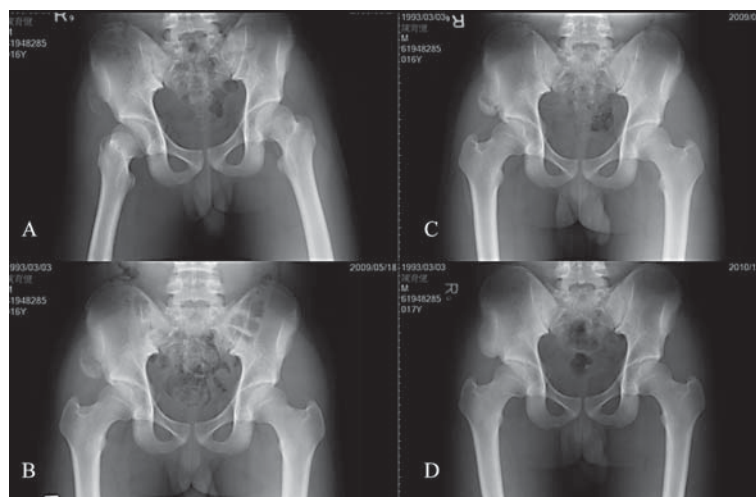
A series of radiographs of the young athlete with avulsion fracture of the anterior superior iliac spine (ASIS) show the healing process. A. Initial AP view of plain radiograph at the ER; B. Callus formation developed 2 months after discharge; C: The avulsed bony fragment has almost healed 5 months after discharge; D: Complete bony healing is seen 20 months after discharge.
